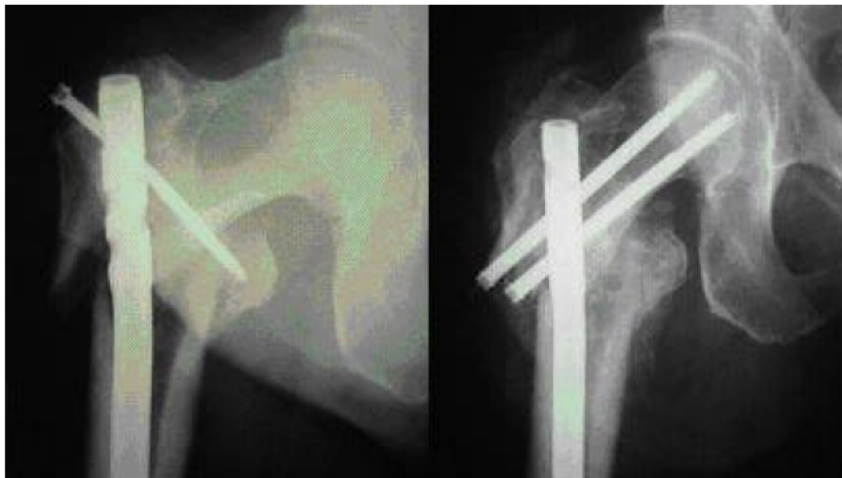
Left, AP radiograph at five weeks showing varus deformity at the fracture. Right, post revision to reconstruction femoral nail
